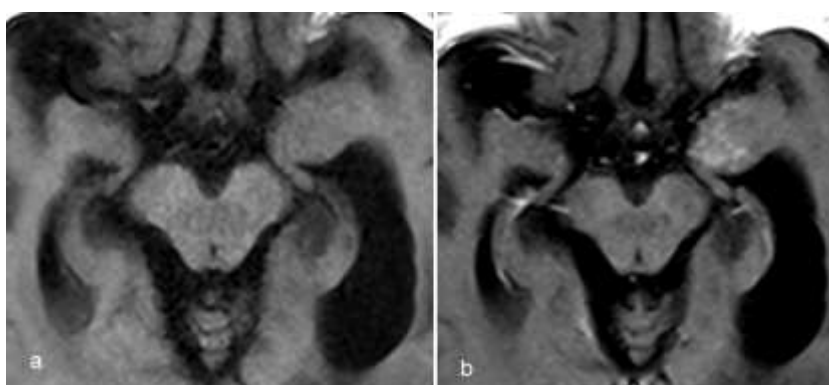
T1-weighted axial image (a) shows a Grade II astrocytoma on the left uncus which is more apparent after contrast administration (b).
